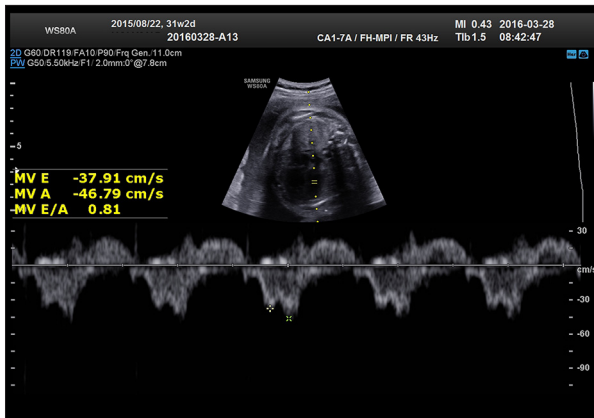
Ultrasound Doppler spectrum of fetal MV in the control group.
